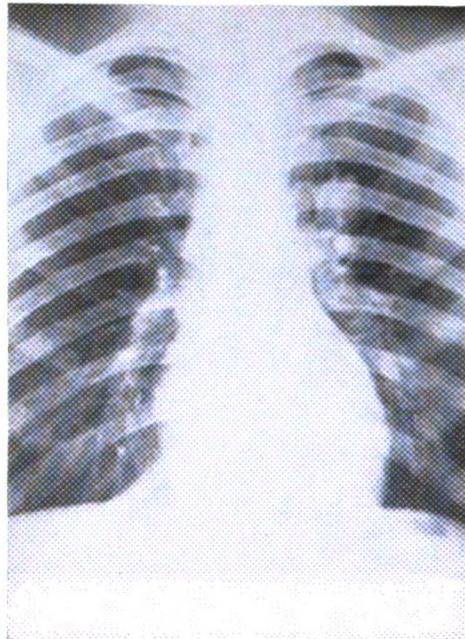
P.A. chest radiograph showing pulmonary opacity in the left upper lobe
